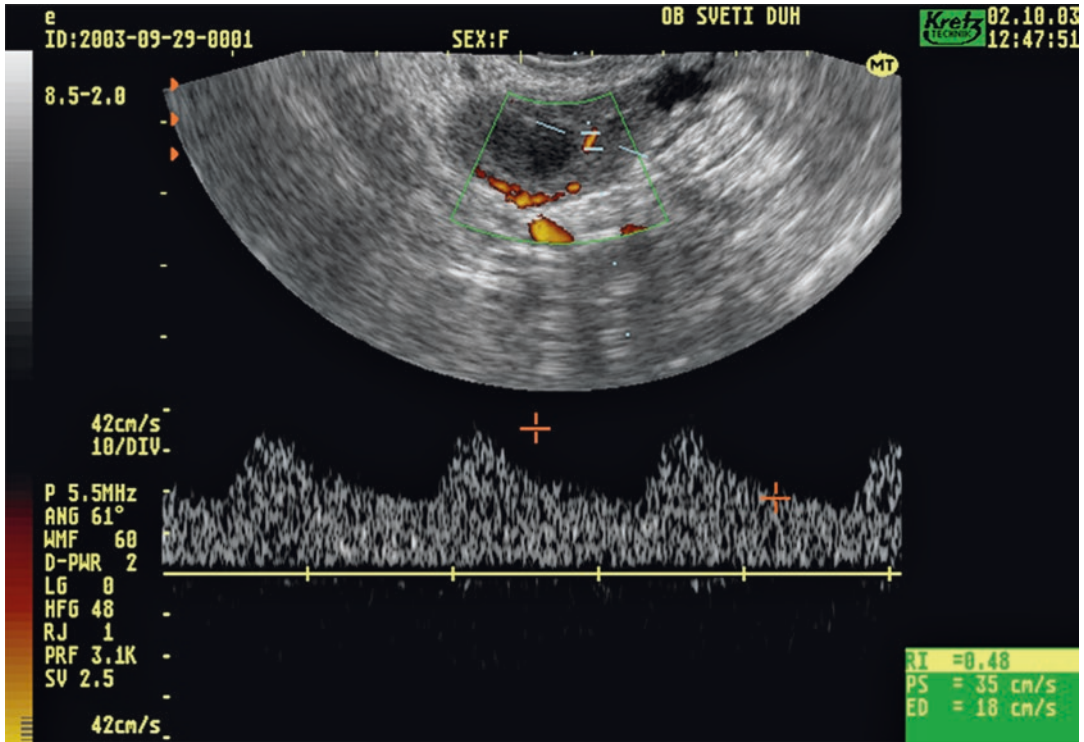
Transvaginal color Doppler image of corpus luteum blood flow
